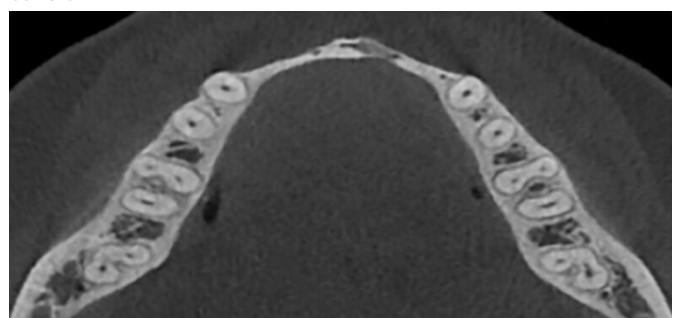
CBCT Axial Cross-Section Showing the Bilateral Occurrence of C-Shaped Root Canal Systems
